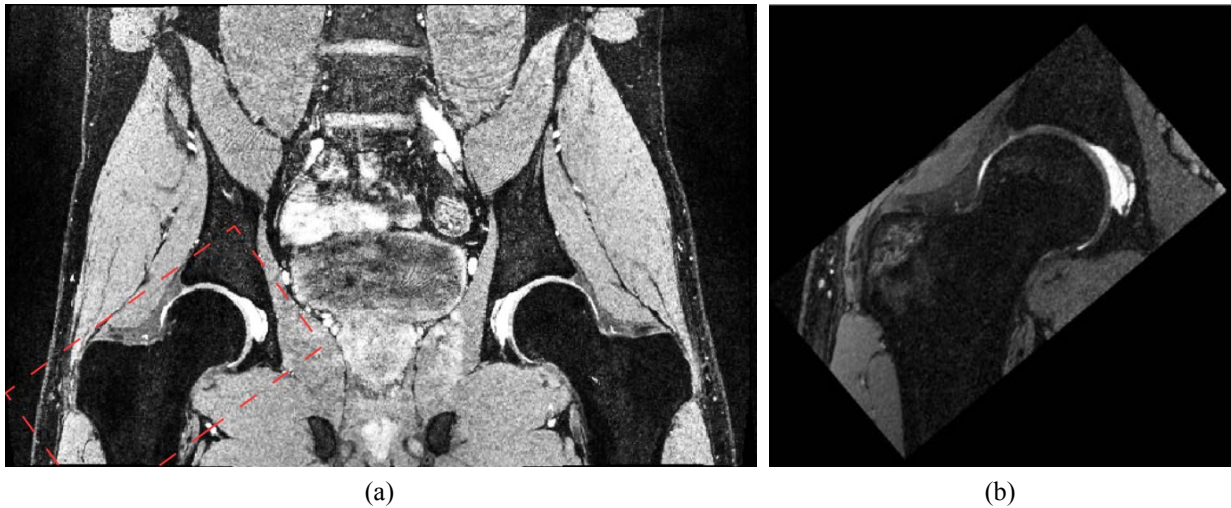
Example coronal slices of MR images acquired from the same subject using (a) bilateral DESS and (b) unilateral TrueFISP sequences. (Red dash line in (a) the DESS image slice (a) indicates a small FOV used in (b) the paired TrueFISP examination.)
